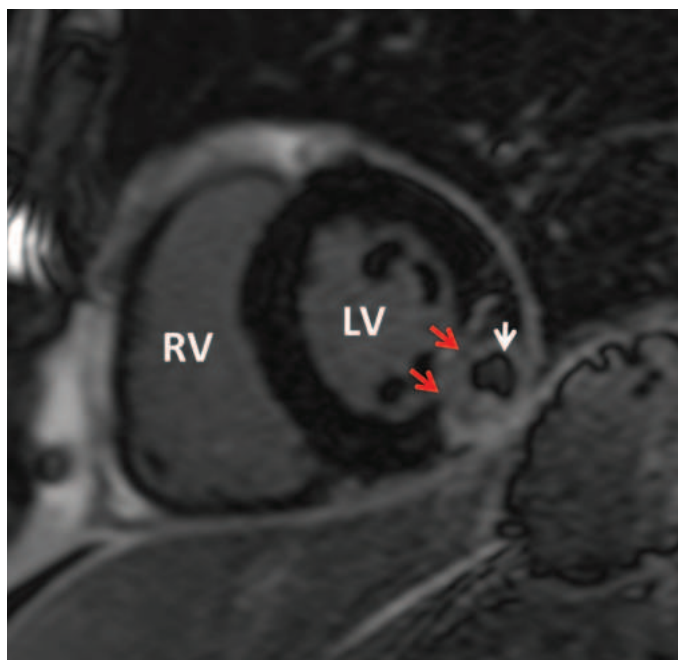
Example of a patient who presented with inferior ST-segment elevation myocardial infarction (MI) after several days of intermittent chest pain. Magnetic resonance imaging (MRI) confirmed an inferior MI by the location of late gadolinium enhancement (LGE; red arrows). In addition, there is a central area of microvascular obstruction (dark region surrounded by the bright LGE, white arrow). LV, left ventricle; RV, right ventricle.
